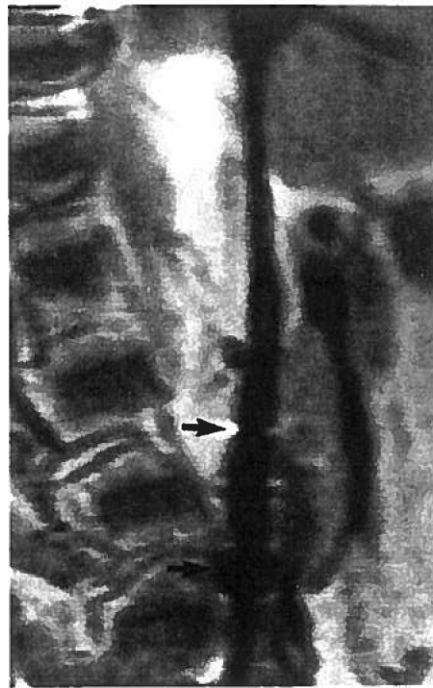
Sagittal MR image demonstrating characteristic appearance with minimal artifact (arrows indicate upper and lower extents of filter).
